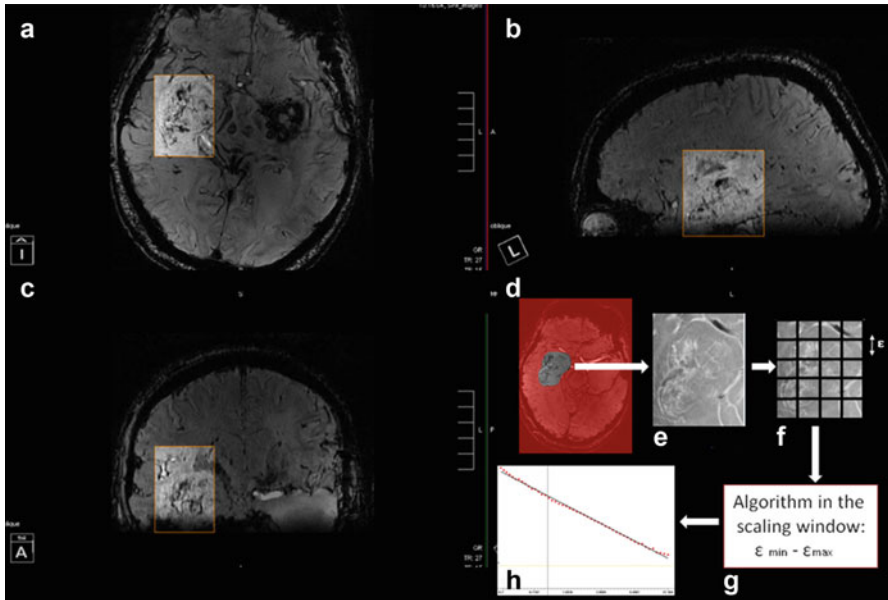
Method used for fractal analysis of 3 and 7 T MR-SWI images. In the example, (a) axial, (b) sagittal, and (c) coronal sections of 7 T MR images (Magnetom 7 T, Siemens Healthcare, Erlangen, Germany, performed at the Medical University of Vienna, Austria) centered on a recurrence of GBM (in the insets). In (d), the region of interest was extracted (i.e., the tumor), and (e) there were segmentation and subsequent binarization of the SWI patterns (in the figure, the signal has been inverted, i.e., the SWI black hypointensities appear here as white). (f) Superimposition of the grid of boxes of ϵ size. The Z-axis sequential sections for the 3D reconstruction are shown according to the algorithm in Fig. 20.2. (g) Repetition of the algorithm with ϵ of different sizes in the scaling window ranging from $\epsilon_{\min} = 0.23$ to $\epsilon_{\max} = 23$ mm (10% increment of the box size at each step until to reach ϵ_{\max}). (h) Results plotted on a log-log graph (x-axis, ϵ , the side length of the box; y-axis, $N(\epsilon)$, on the grid, the number of boxes of ϵ side which cover completely the SWI patterns). The slope of the graph of $\log [N(\epsilon)]$ against $\log (1/\epsilon)$ represents the fractal dimension. The software for the analysis was developed in visual C++ language by Carlo Russo (Reproduced from Di Ieva et al. [21] with permission of the Publisher)
